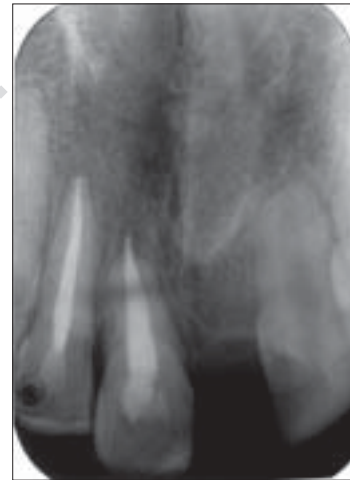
Intra oral periapical radiograph at six month follow up.
